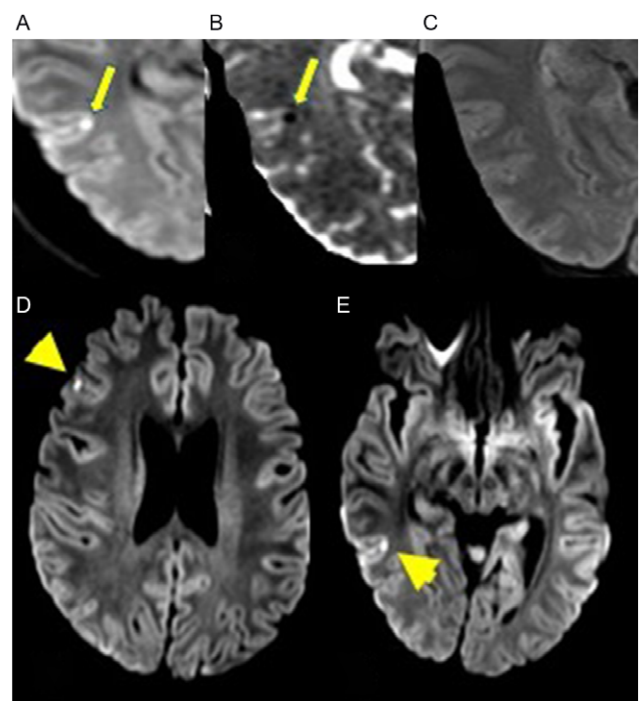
Brain MRI. Axial DWI (A) shows a punctate cortical hyperintense lesion with corresponding hypointensity on ADC (B) and subtle hyperintensity in FLAIR (C) compatible with ischemic lesion. Axial DWI images (D and E) show other punctate hyperintense lesions involving the cortex of the symptomatic hemisphere.
